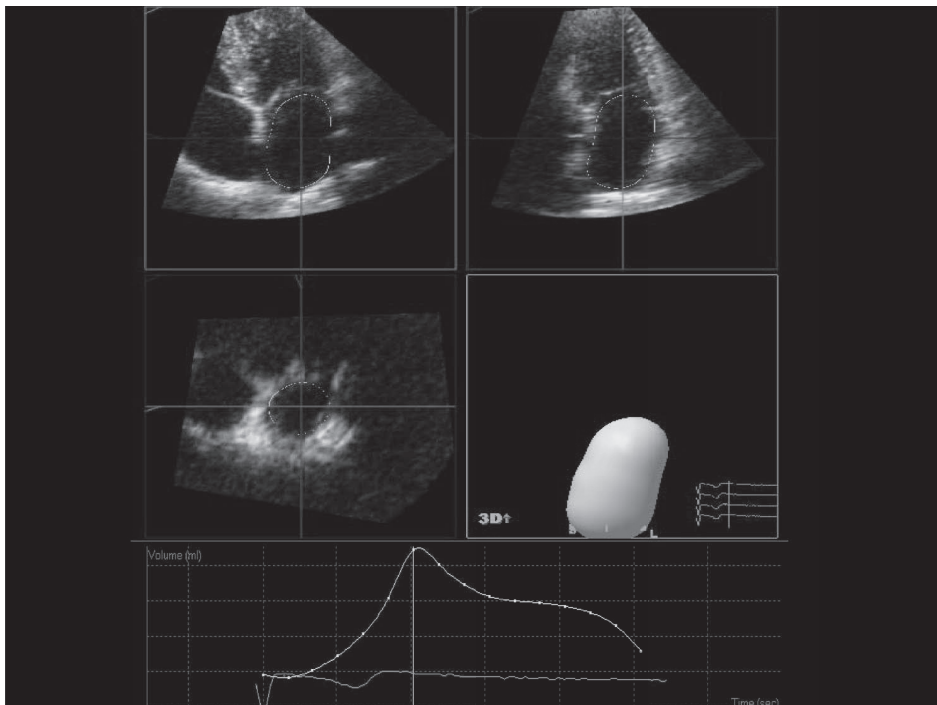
Assessment of LA volumes using RT3DE. An automatic border detection is obtained marking 5 reference points in the apical 2- and 4-chamber views (upper panel) and the LA 3D model is provided by the software. The changes of LA volumes during the heart cycle are plotted as a curve (lower panel).
